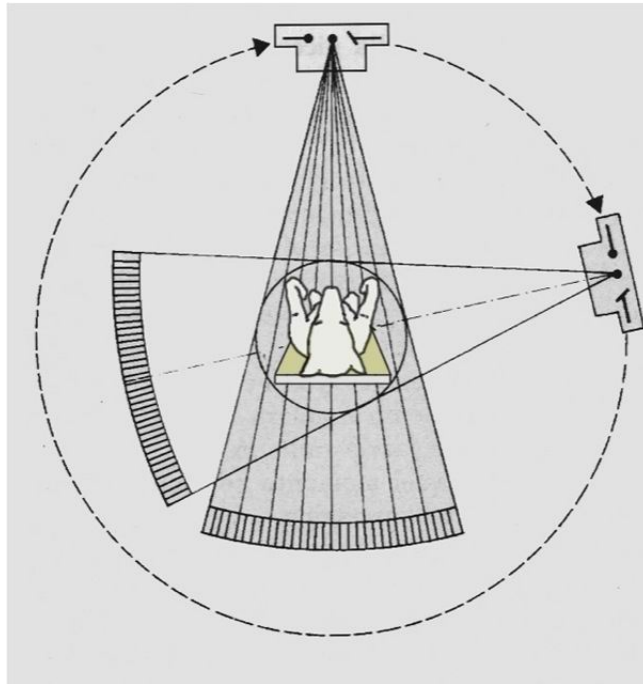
A representation of third generation CT scanner (Fan Beam, Rotate only).
